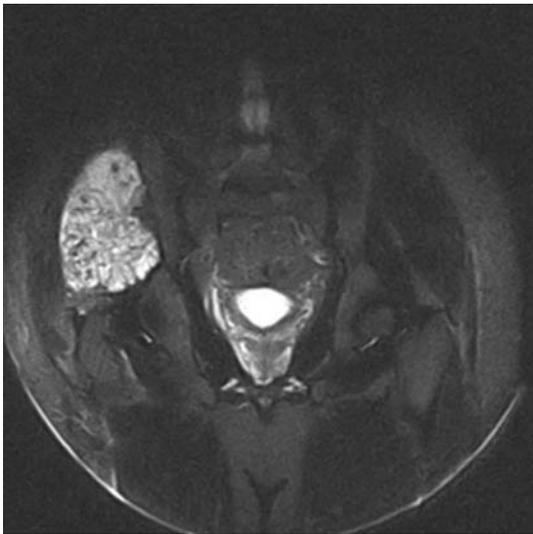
Coronal T2 MRI of Figure 33.7, note the sessile osteochondroma of origin.
